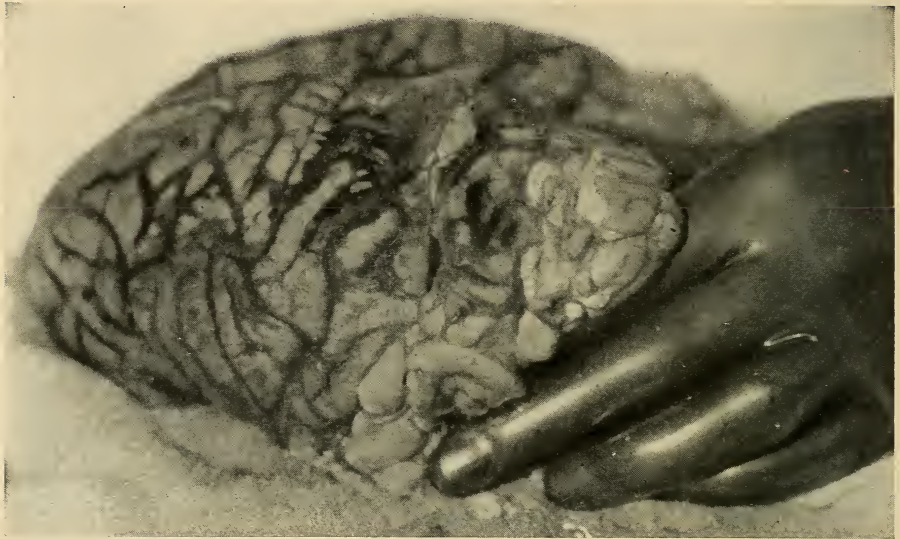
Henry W. Extensive supracortical and subarachnoid hemorrhages associated with acute medullary edema, but no fracture of the skull, in a man who had fallen, while asleep, from a fire-escape to the ground—a distance of twelve feet; marked stupor upon admission to the hospital two hours after the injury (2 A.M.). As there were no signs of a "fracture of the skull," such as bleeding from the nose, mouth or ears, et cetera, and since the general condition of the patient "seemed good," it was decided to "wait until morning" and then have an "X-ray picture taken." At 7 A.M. (5 hours after the injury and 3 hours after admission), the patient suddenly developed extreme signs of an acute medullary edema—the pulse- and respiration-rates quickly ascending to 150 and 50 plus, respectively, so that death occurred at 10 A.M. (8 hours after the injury and 6 hours after admission to the hospital). An autopsy did not reveal a fracture of the skull. Careful repeated examinations could have, at least, anticipated this unfortunate result.
